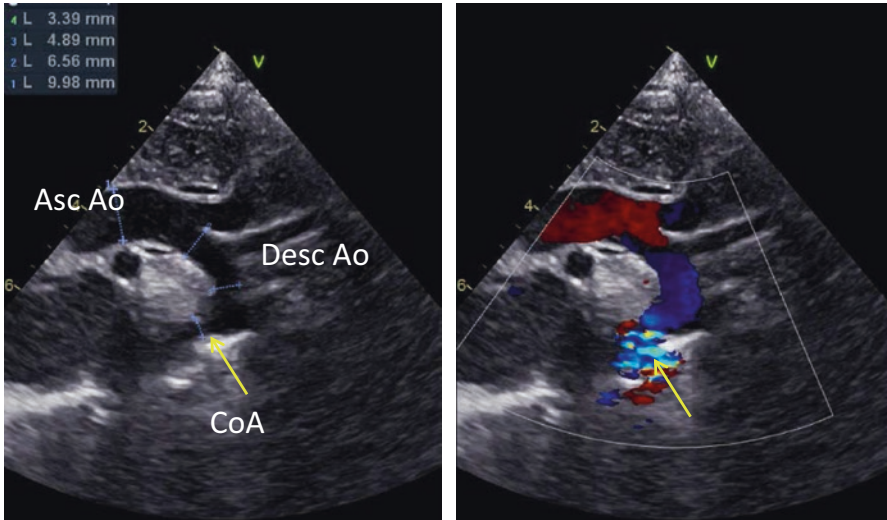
Suprasternal: narrowing of the descending aorta (arrow = coarctation) in juxtaductal position with aliasing of flow by color Doppler
